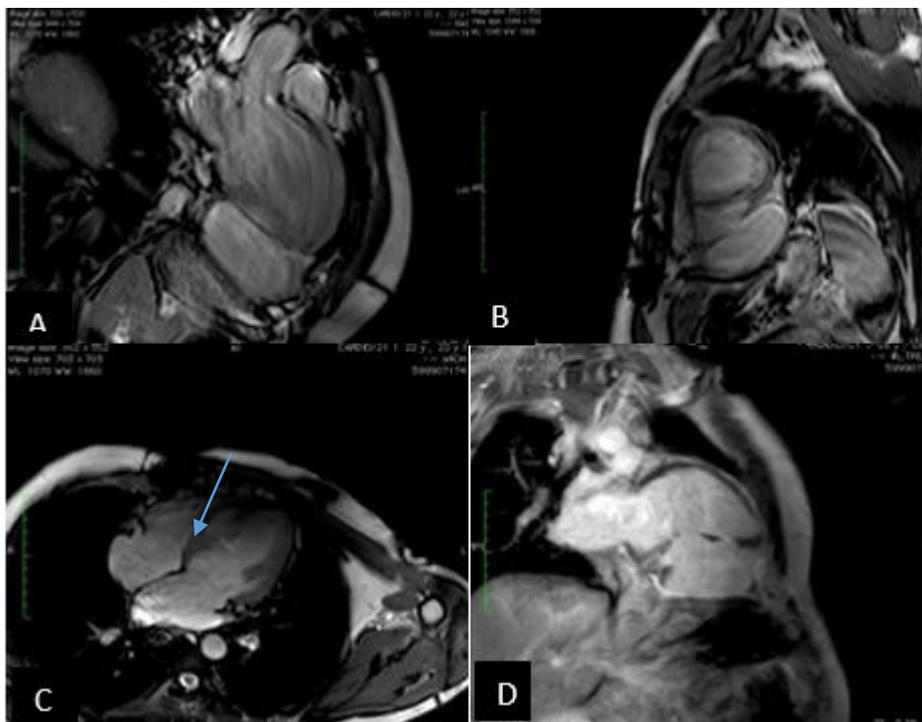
MRI 6 months later : (A)(B) 2-chamber and Mid ventricular Schort axis views showing a cyst with clear content in the infero-lateral and inferior wall respectively. (C) 4-chamber view showing the communication between the cyst and the left ventricle with a bidirectional shunt. (D) 2-chamber view showing contrast enhancement at the periphery of the cyst.
